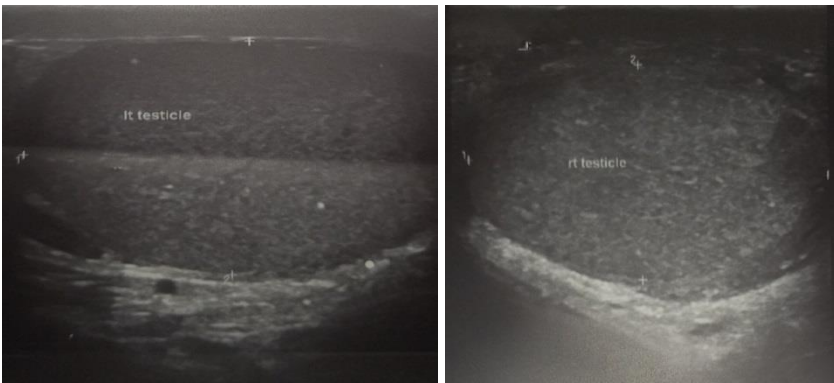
Scrotal Doppler ultrasound (post treatment).
